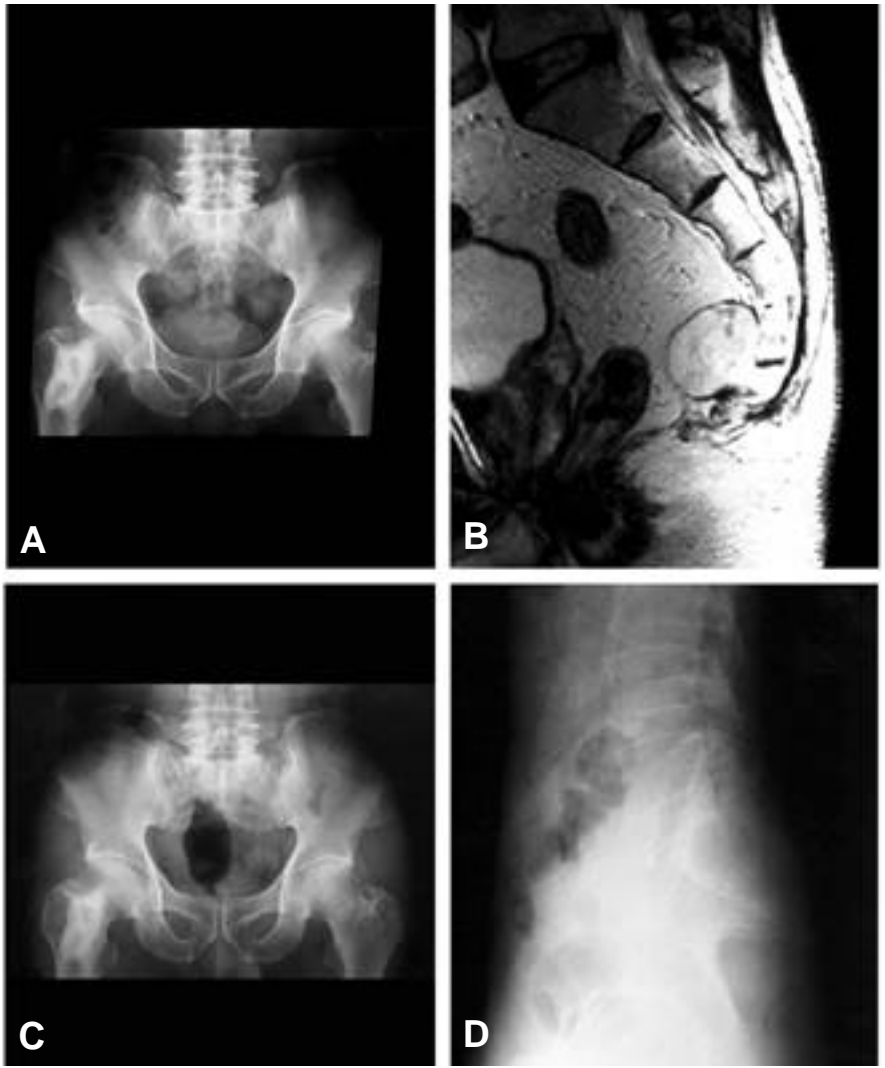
67-year-old male had a coccygodynea for a month. (A) Plane radiograph shows an osteolytic destruction of the right distal area. (B) T-2 weighted sagittal magnetic resonance image shows uneven signal intensity mass arising from the sacrococcygeal junction. (C and D) After partial sacrectomy at S3 segment, there was no local recurrence or metastasis at 9 years follow-up.
